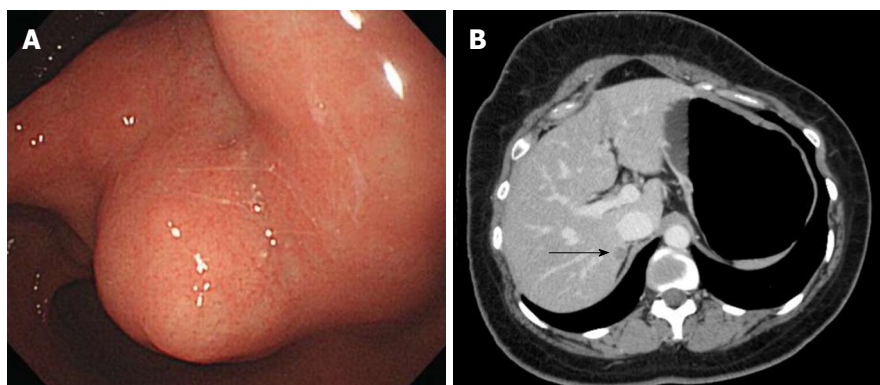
Esophagogastroduodenoscopy. A: Gastroendoscopy revealed an antral submucosal tumor without ulceration and hemorrhage; B: Computed tomography revealed a hypoattenuating nodule in segment VII of the liver, with peripheral weak enhancement in the portal phase (arrow).
